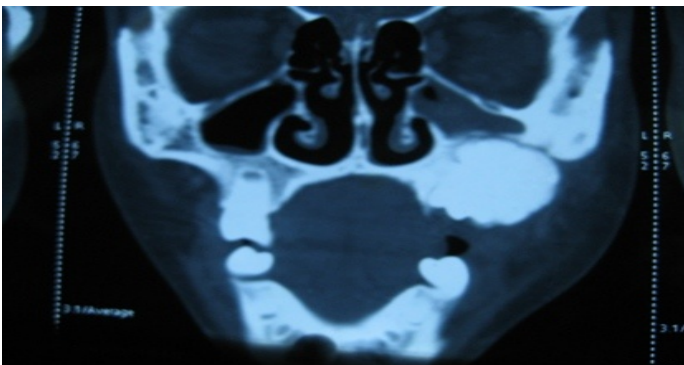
Computed tomographic images showing a large well-defined smoothly margined, lobulated expansile lesion involving the left maxilla and the whole left maxillary antrum, which was calcified.
